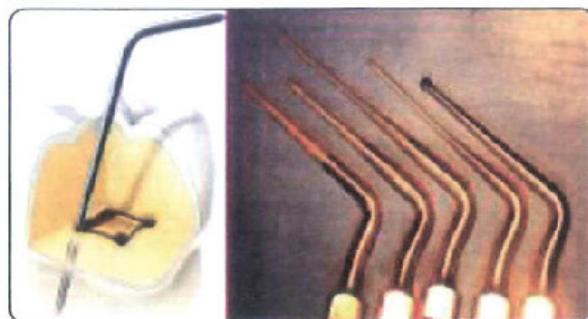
Several ultrasonic tips used during access cavity preparation for uncovering dentin shelves covering canal orifices
